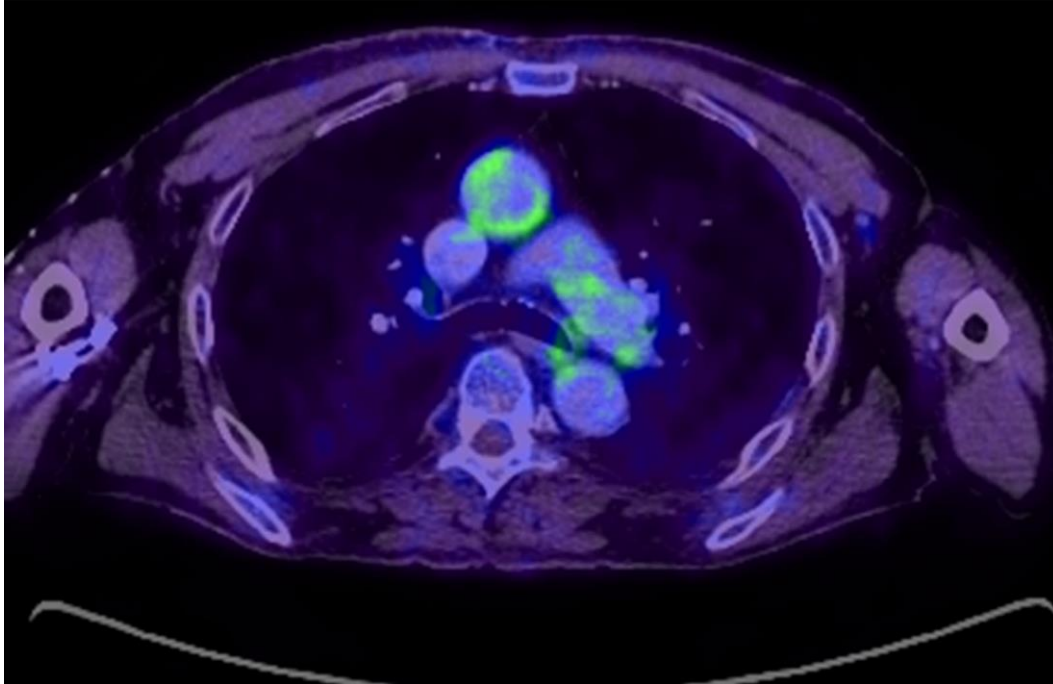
Axial slice of fused PET/CT image of an HIV-infected patient showing increased ¹⁸F-FDG uptake in the wall of the ascending aorta
